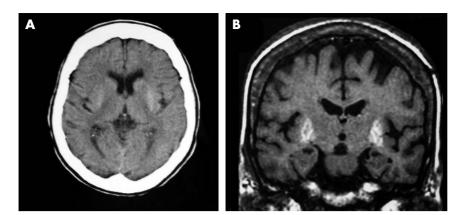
Image findings. (A) CT brain scan on admission—bilateral hyperdense putamen and caudate nuclei. (b) MRI brain scan conducted 2 weeks after admission—bilateral hyperintense putamen on T1W images.
